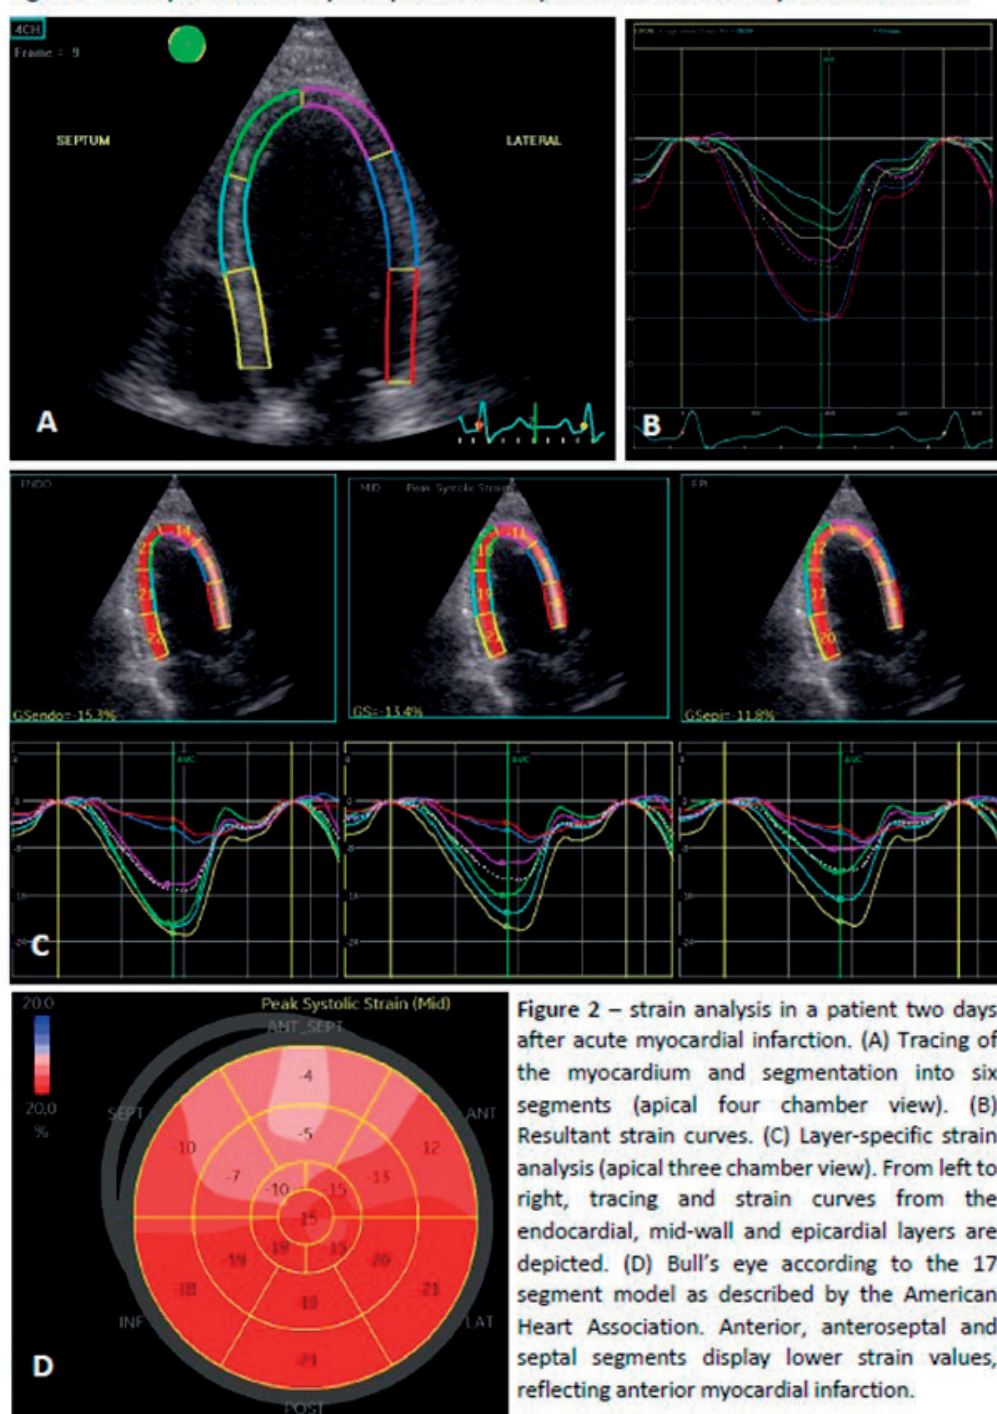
strain analysis in a patient two days after acute myocardial infarction. (A) Tracing of the myocardium and segmentation into six segments (apical four chamber view). (B) Resultant strain curves. (C) Layer-specific strain analysis (apical three chamber view). From left to right, tracing and strain curves from the endocardial, mid-wall and epicardial layers are depicted. (D) Bull's eye according to the 17 segment model as described by the American Heart Association. Anterior, antero-septal and septal segments display lower strain values, reflecting anterior myocardial infarction.
